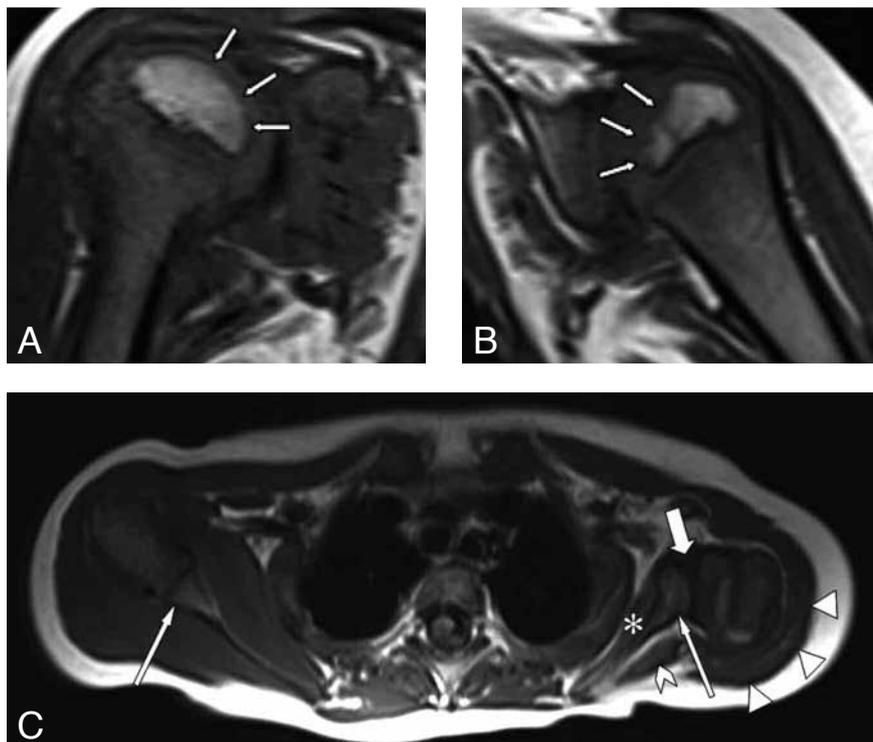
Coronal T1 (A, B) and axial T1 (C) MR images show asymmetric size of proximal epiphysis (short arrows) with glenoid dysplasia (long arrow).
